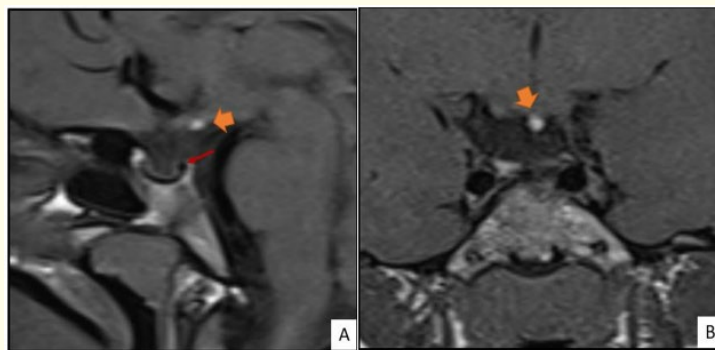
Sagittal (A) and coronal (B) sections of a hypothalamic-pituitary MRI in T1-weighted sequence showing an ectopic posterior pituitary at the level of the infundibulum (Orange arrow), a non-visualized pituitary stalk, and a hypoplasia anterior pituitary (Red arrow).
